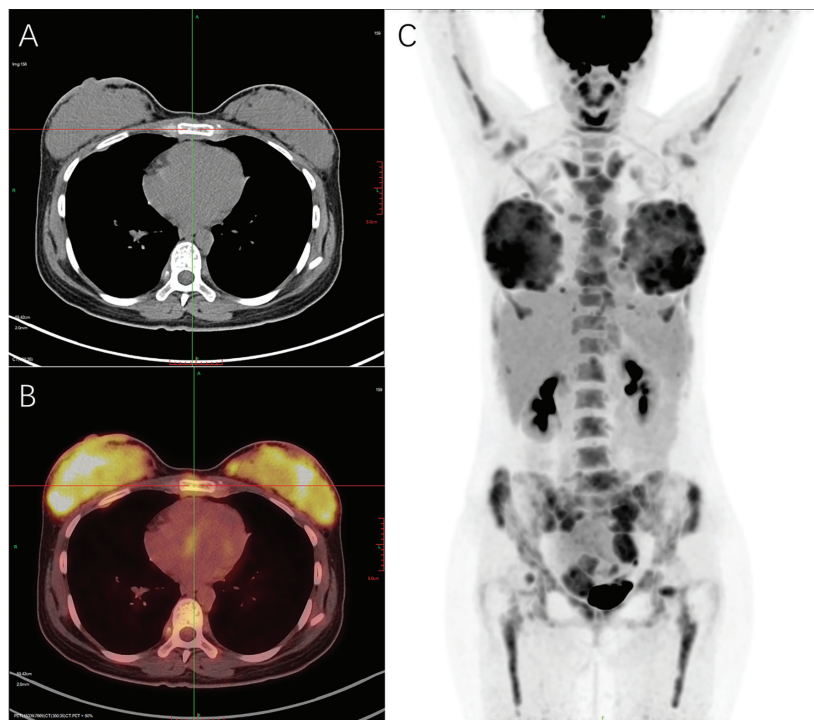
F-18 FDG PET-CT findings, (A) CT images show bilateral, dense, and full breast tissue with skin thickening, (B) PET images reveal diffusely increased but uneven radiotracer uptake in both breasts, with an SUV_{max} of 7.4, (C) Coronal maximum-intensity projection images demonstrate widespread systemic metastases.
